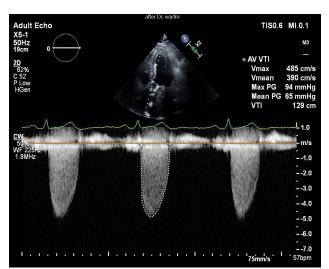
Echocardiography Doppler one month after discontinuation of Warfarin.
